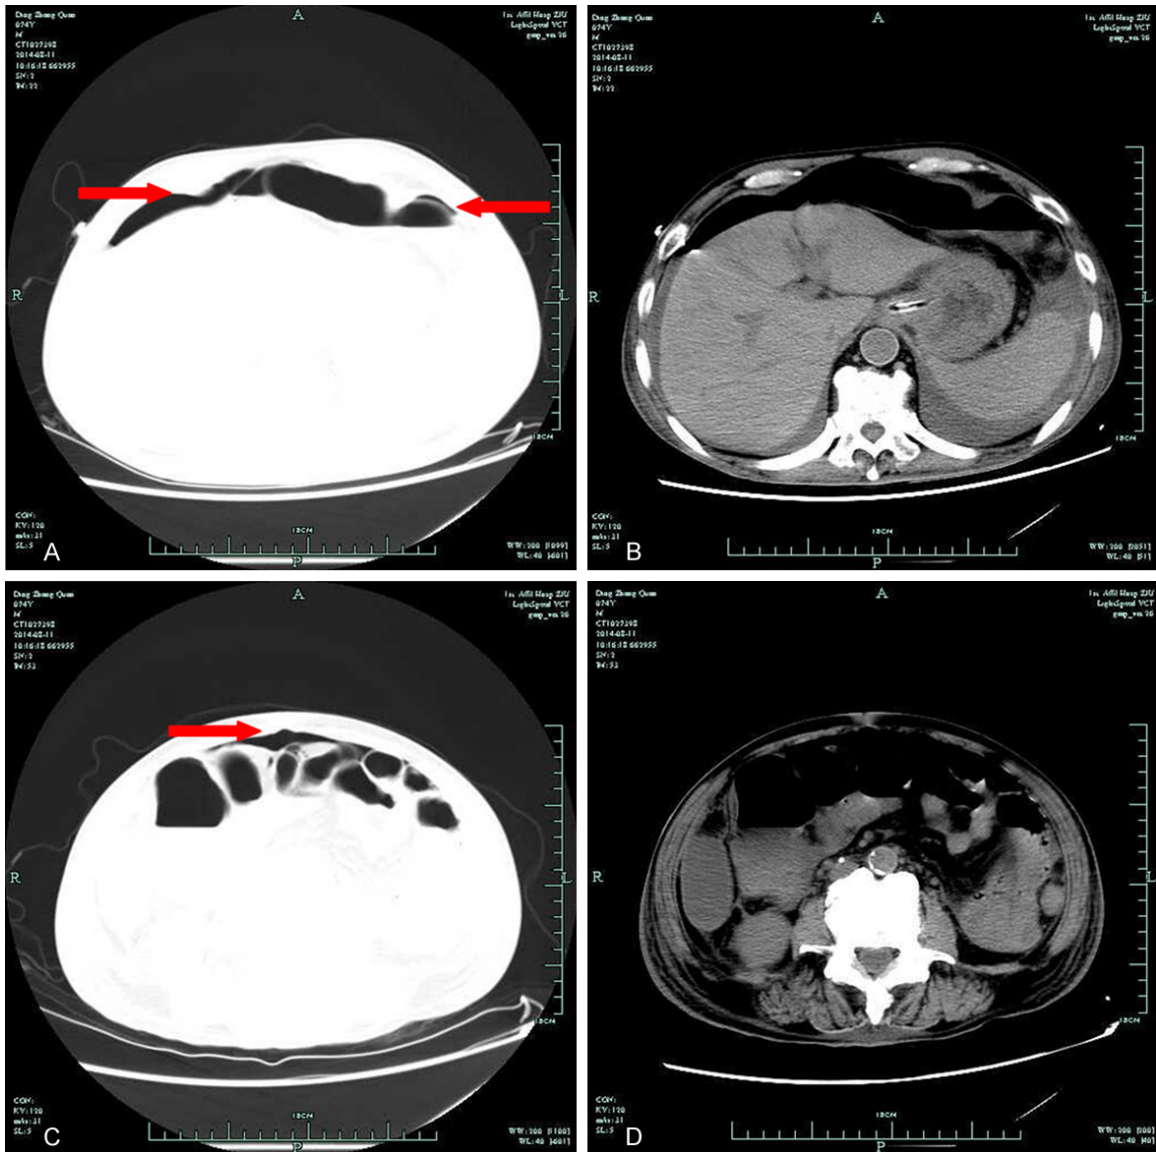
An abdominal CT scan documents intraperitoneal free gas. A and C. Adjustment pictures to display intraperitoneal free gas as red arrows showed; B and D. Original pictures.
